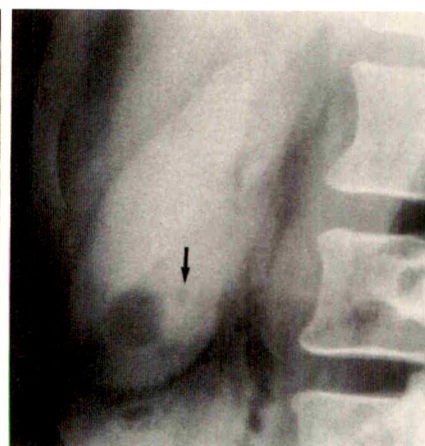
Cholecystographic-sonographic correlation. Oral cholecystography shows size and number of stones.
